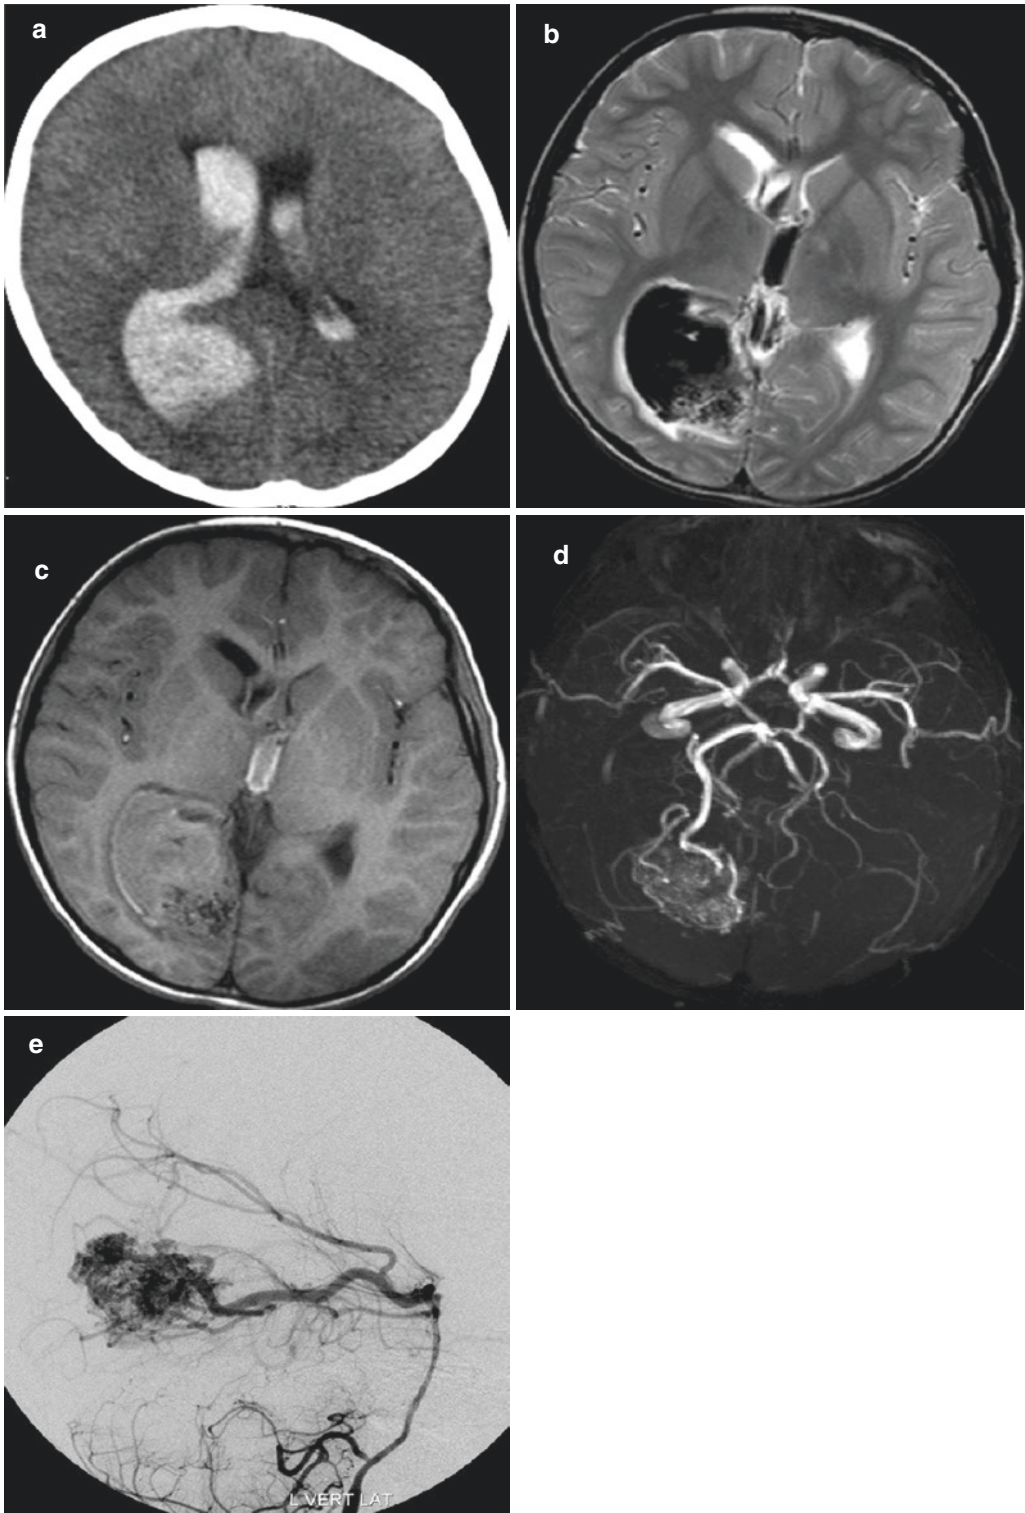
AVM hemorrhage. (a) Noncontrast CT shows right occipital acute hematoma with extension to the ventricles. Hematoma is hypointense on T2W (b) and isointense on T1W (c) images. Note that subtle signal voids at the posterior
